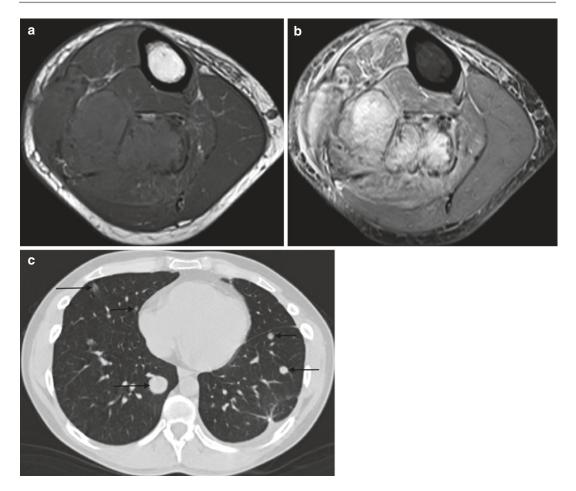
(a–c) Malignant tenosynovial giant cell tumour (*TSGCT*) of the calf. Axial T1-weighted (a) and STIR (b) MR images. (c) Axial CT of the chest. There is an intermediate to slightly hyperintense SI relative to skeletal muscle on T1-weighted images within the deep compartment of the lower leg (a). The mass is hyperintense on
